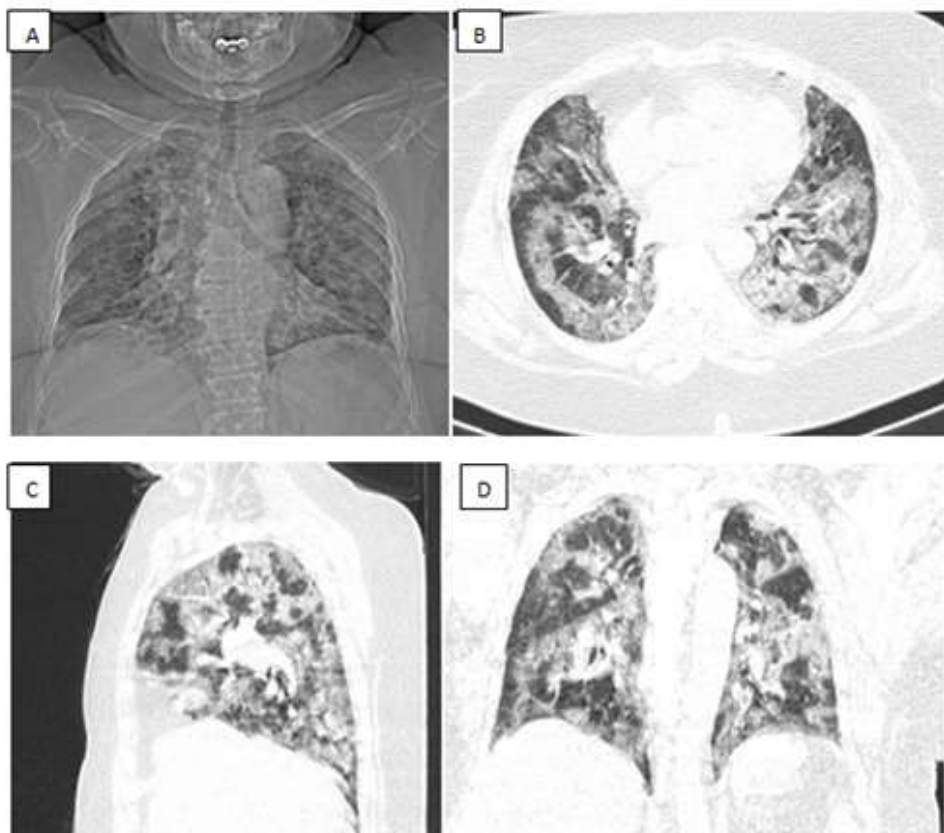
Radiograph (A), and CT axial (B), coronal (C) and sagittal (D) images of a 60 year old female patient showing extensive ground glass opacities. The CTSI score of patient was 18/25 (Severe) and SPO2 of patient was 72%.
